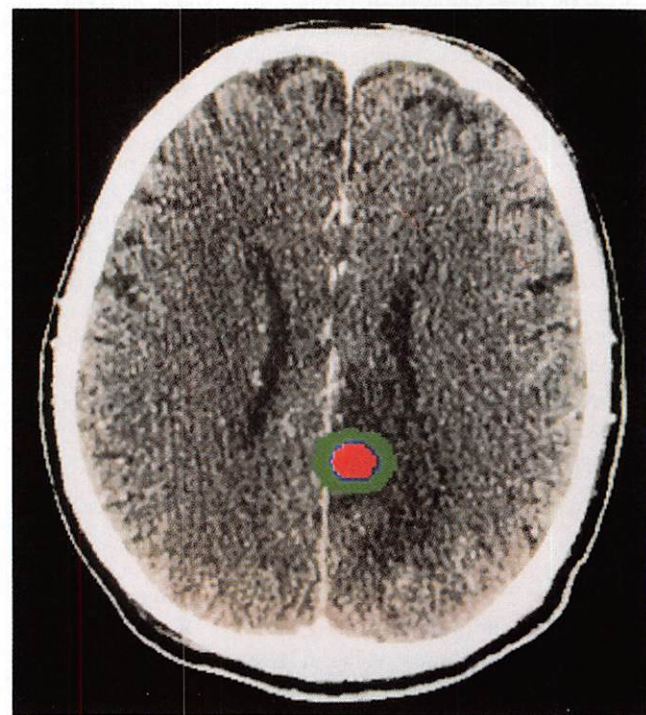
Typical dose distribution superimposed on transaxial CT image. Tumor is included in area bounded by 80% isodose line (red), surrounded by narrow zone of rapid falloff in dose (blue; limited by 50% and 80% isodose lines).
